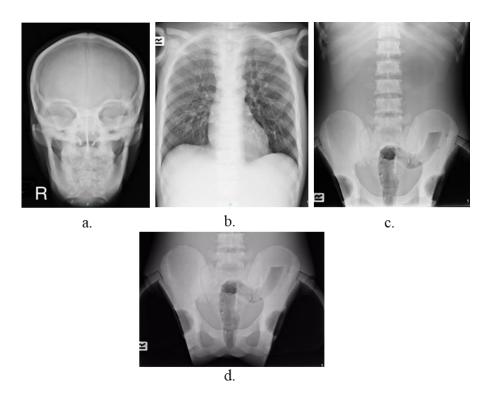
Radiography of skull (a.), chest (b.), abdomen (c.), pelvis (d.)
